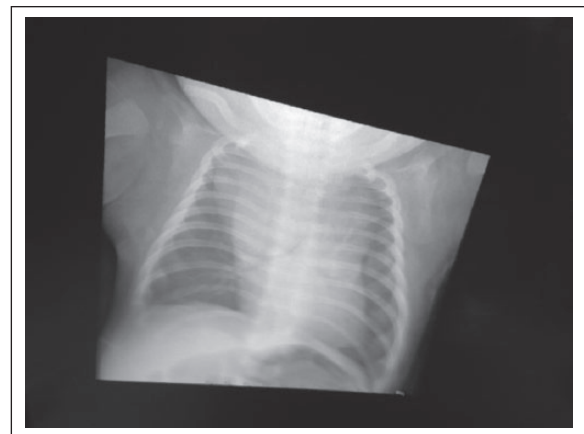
Radiograph obtained in the emergency department was concerning for a mediastinal mass.
